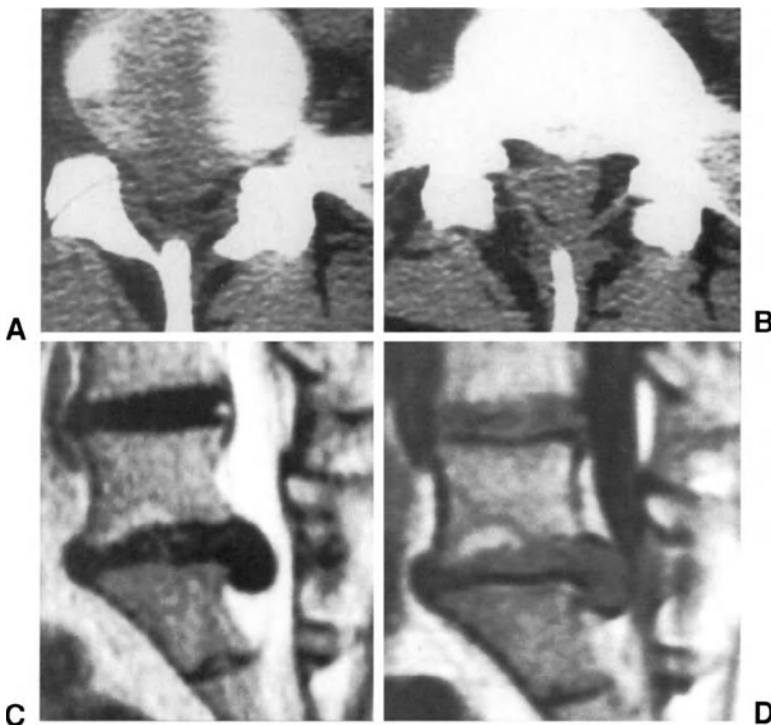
L5-S1 disc herniation showing a low density and, thus, poorly distinguishable from the thecal sac on axial CT scans. The CT scan at the level of the disc (A) appears to display a focal convexity of the disc border and compression of the thecal sac. However, on the CT scan at the level of the S1 vertebral end-plate (B), the disc herniation cannot be distinguished from the thecal sac. The turbo spin-echo T2-weighted (C), and the spin-echo T1-weighted (D), MR images show a large disc herniation which extends caudally to the S1 vertebral end-plate. On the turbo T2-weighted image, the lower two lumbar discs show a marked hyposignal due to degenerative changes and a punctiform hyperintense area is present in the posterior portion of L4-L5 annulus fibrosus.
